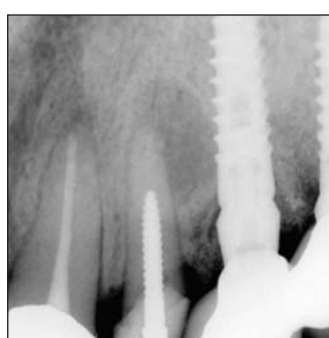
X-ray of the implant at the location of tooth # 23
